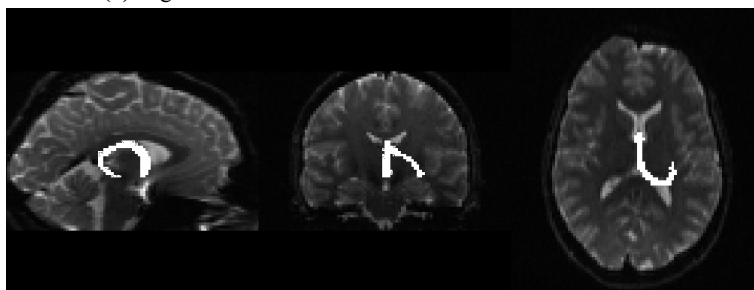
Image from the quality control. The segmentation of each tract is projected onto the diffusion MRI image of that individual.
